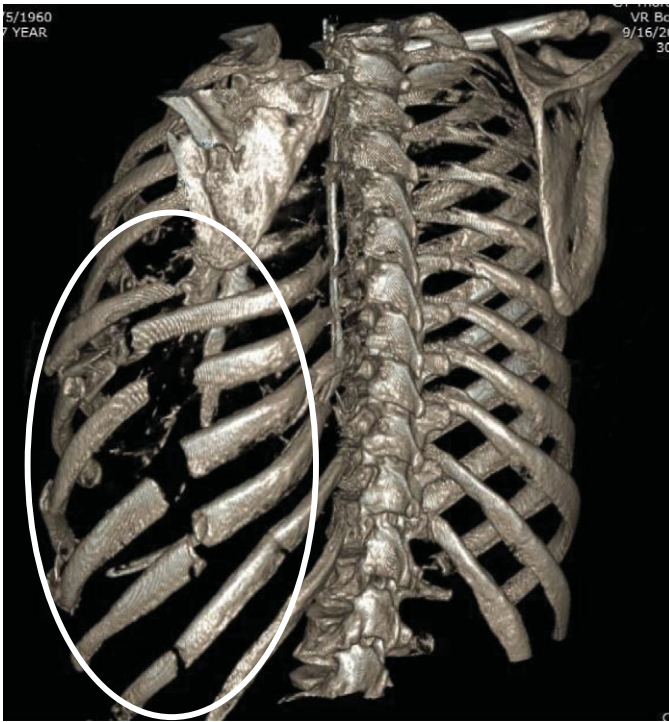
3D computed tomography reconstruction demonstrating a flail chest segment with multiple double rib fractures (circle).
